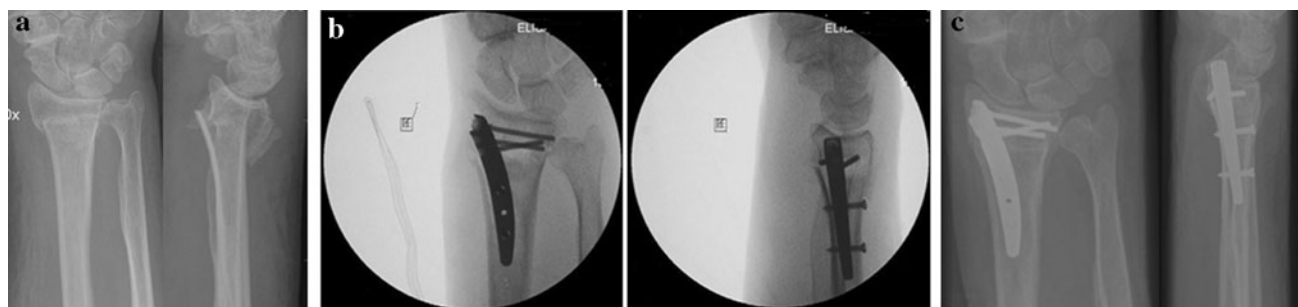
a X-rays of the right wrist in a 78-year-old female, after a collapse; a two-part dislocated fracture can be seen. b Anteroposterior and lateral radioscopic view during surgery, after positioning the Micronail®. c Control X-ray of the wrist after 4 months of follow-up
